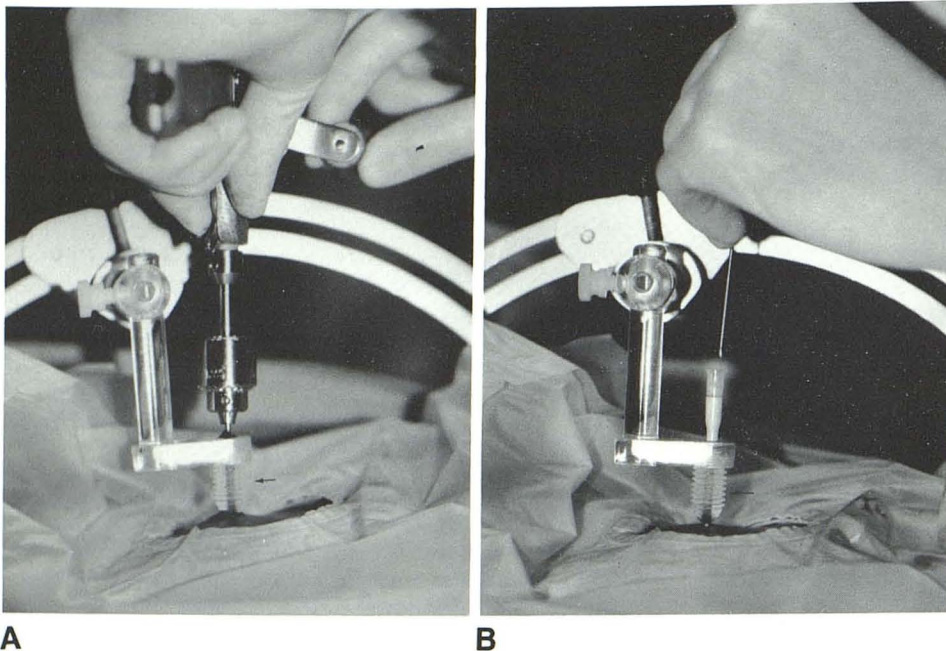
A, Placing bit of twist drill or craniotome through drill guide core (arrow) ensures precise placement of narrow hole. B, Biopsy needle is then placed into craniotomy through needle guide core (arrow) and is advanced downward through brain into lesion in serial stages monitored by intraprocedural control CT scans.
